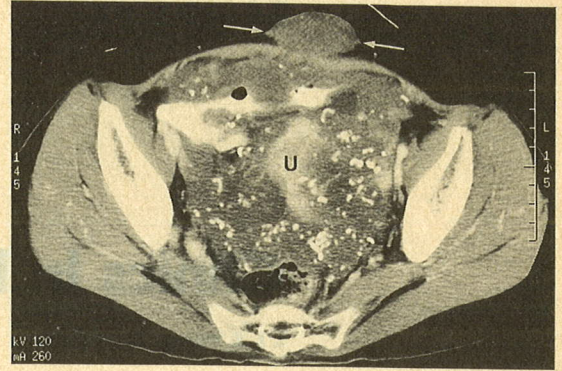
Post-contrast CT of the pelvis, taken at the level corresponding to Fig 3. There is heterogeneous enhancement of a subcutaneous tumour deposit (arrows) located anterior to the rectus muscles. Peritoneal carcinomatosis surrounds and scallops the enhanced uterus [U].
